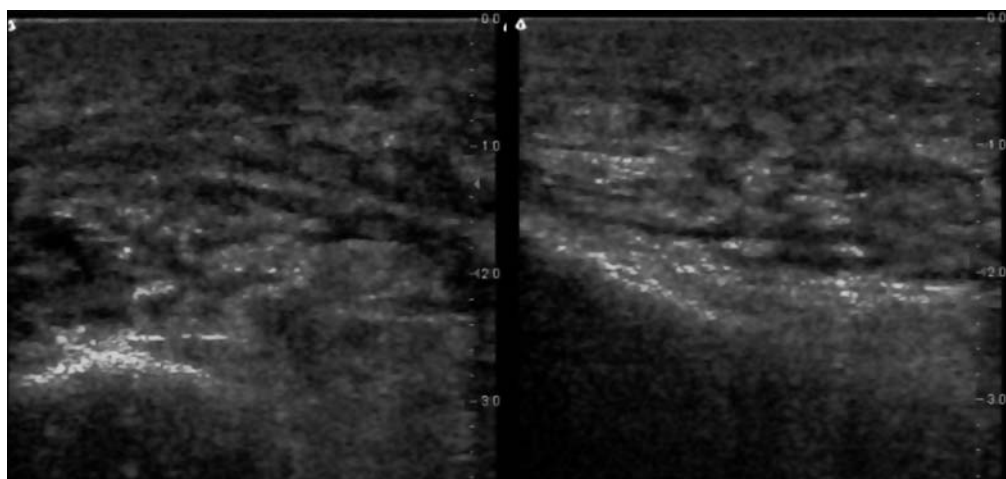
Ultrasound images taken at level of ankle in an individual with LE. *Left:* Image before treatment with manual lymphatic drainage and external compression. *Right:* Image at same location after treatment, demonstrating reduced epifascial thickness.
